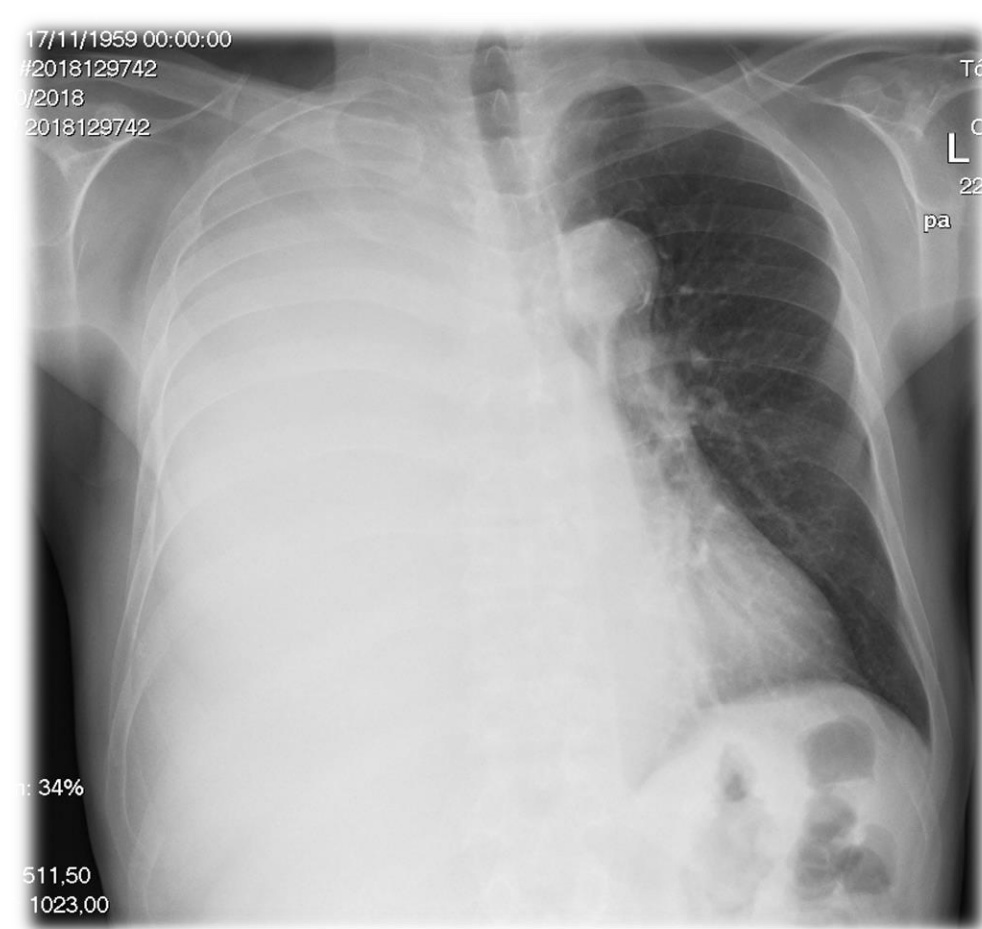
Chest radiography in the Emergency Department
